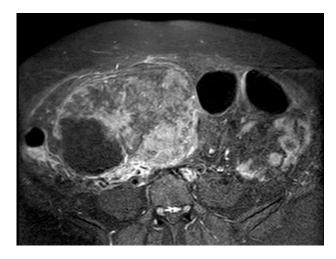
MRI post contrast T1 showing intense heterogeneous enhancement with enhancement of septa.
